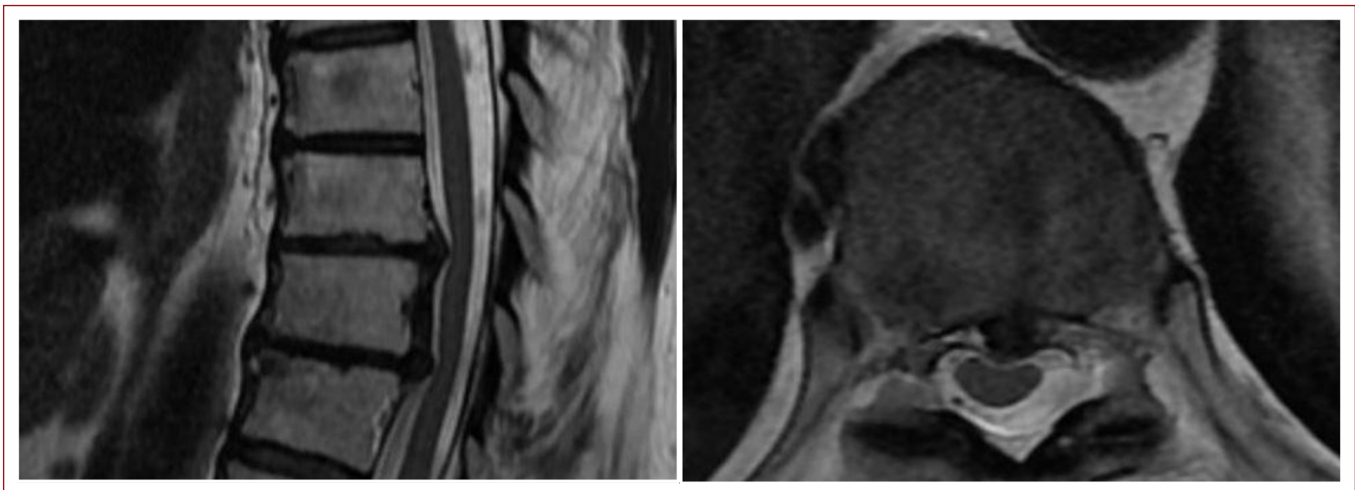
a) Grade 3 degeneration of T9–10 disc of 64-year-old female patient in T2-weighted sagittal image, Grade 4 degeneration of T10–11 disc, b) coalescing central caudal at T9–10 level in axial image, disc hernias extruded to central cranial at T10–11 level.
